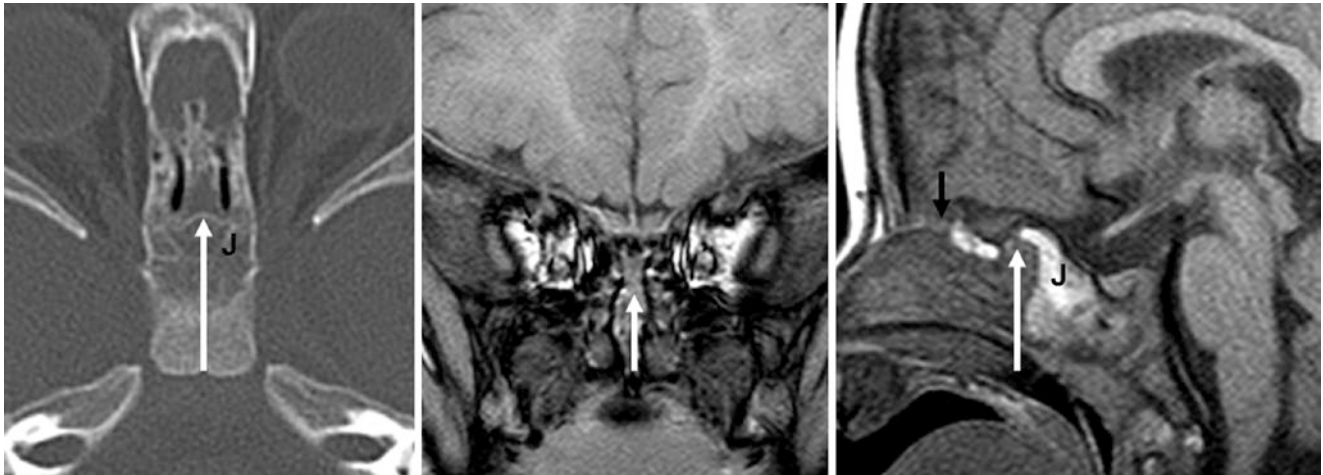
A 1 year old with a larger IED (*white arrows*) on NECT (*left*) and a corresponding defect on MRI with coronal (*middle*) and sagittal (*right*) T1WI. The IED is located between the sphenoid jugum (*J*) and the ethmoid bones. An incidental foramen cecum is noted anteriorly (*black arrow*)
